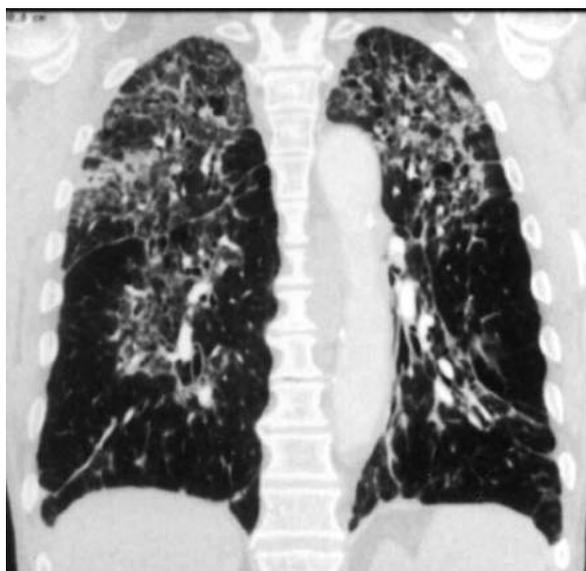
Chest CT in coronal view shows thickened interstitium more prominent in upper lobes
